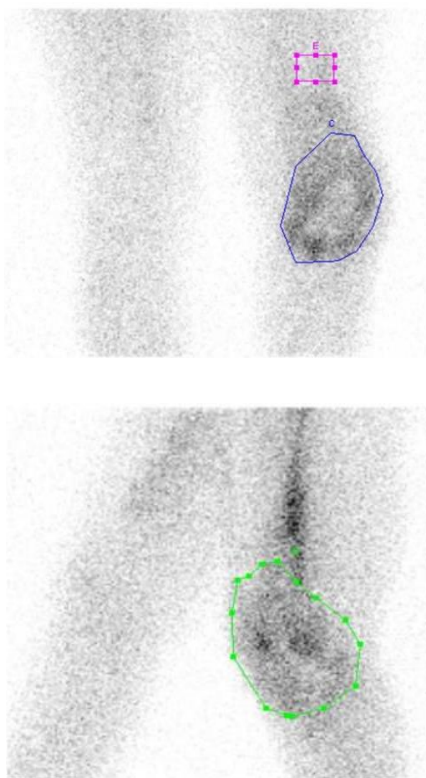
Anteroposterior labeled leukocyte scintigraphy early (1 hour) image of a patient with left knee prosthesis; an example case for demonstration of region of interest including knee region (irregular) and background region (rectangular) (above). Lateral projection bone marrow image of an example patients to demonstrate irregular region of interest covering left knee prosthesis (below).
